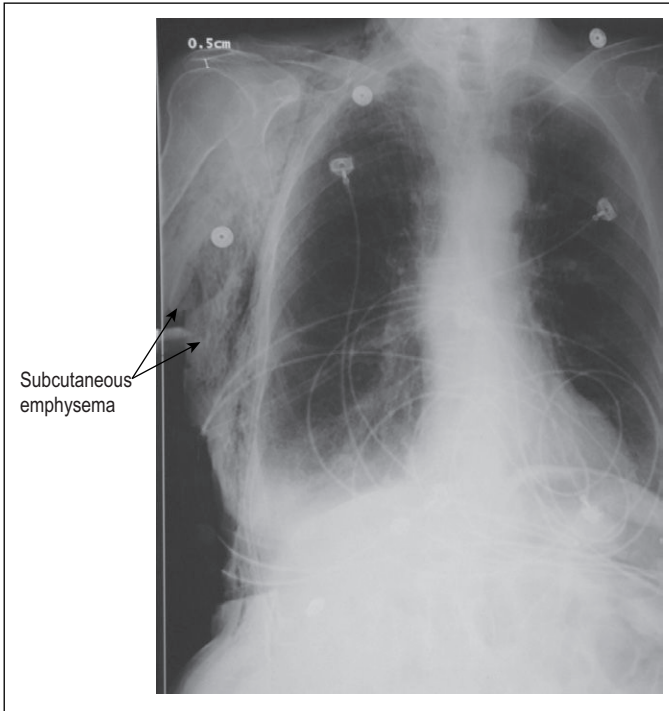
X-ray of subcutaneous emphysema
